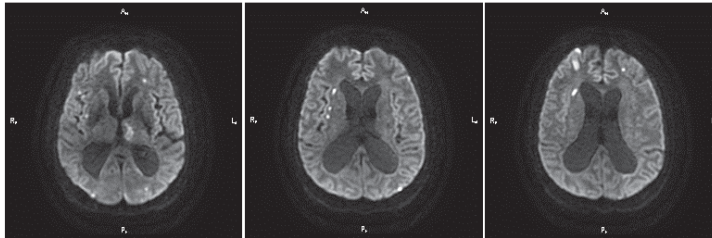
Slices of the brain (magnetic resonance imaging) with multiple foci of acute and subacute ischemia
